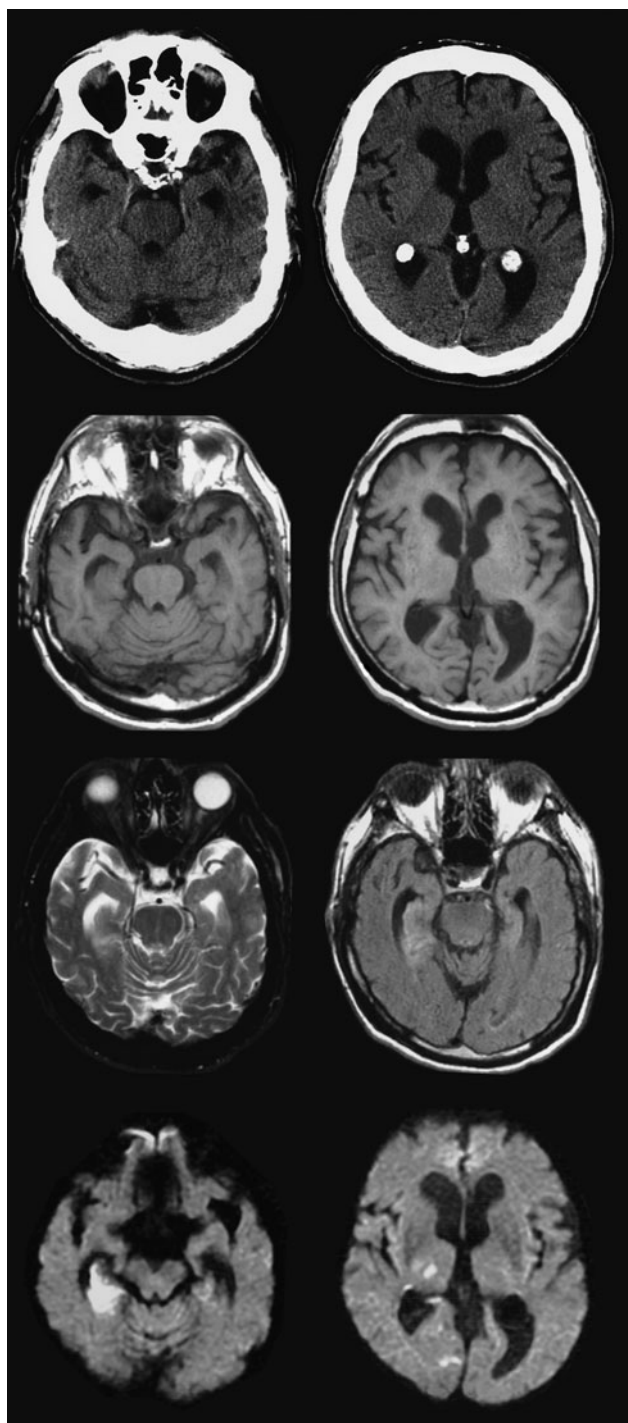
Computed tomography (CT) and magnetic resonance imaging (MRI) sequences identifying vascular lesions and volume loss.
